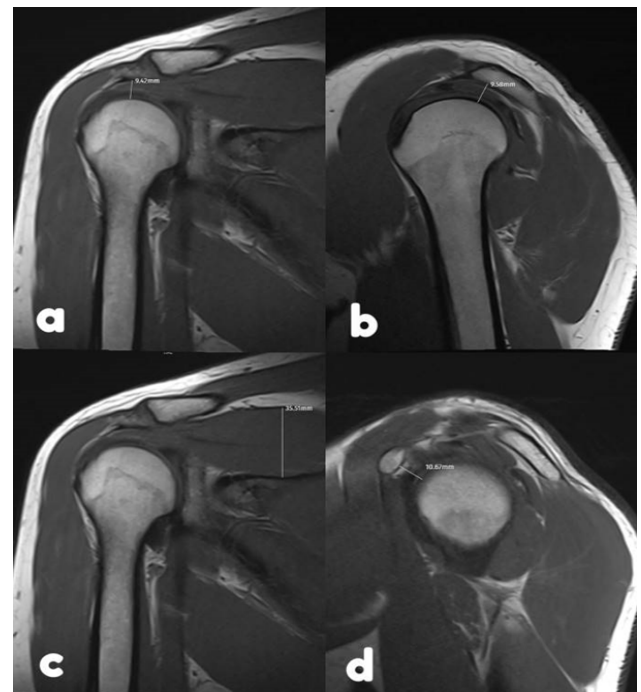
MRI showing the measurement of acromiohumeral distance on (a) coronal, and (b) sagittal T1 images, (c) supraspinatus muscle thickness measurement on coronal T1 image, and (d) the measurement of coracohumeral distance on sagittal T1 image.
